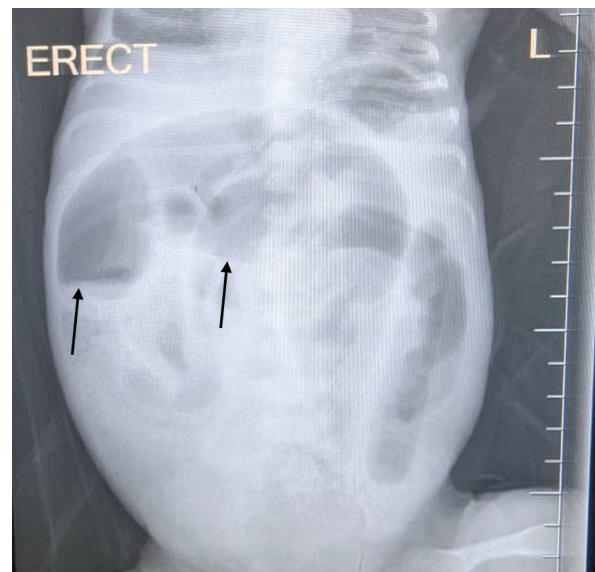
Plain abdominal X-ray showing multiple stacked air-fluid levels (black arrows) with dilated bowel loops, highly suggestive of a distal small-bowel obstruction.
